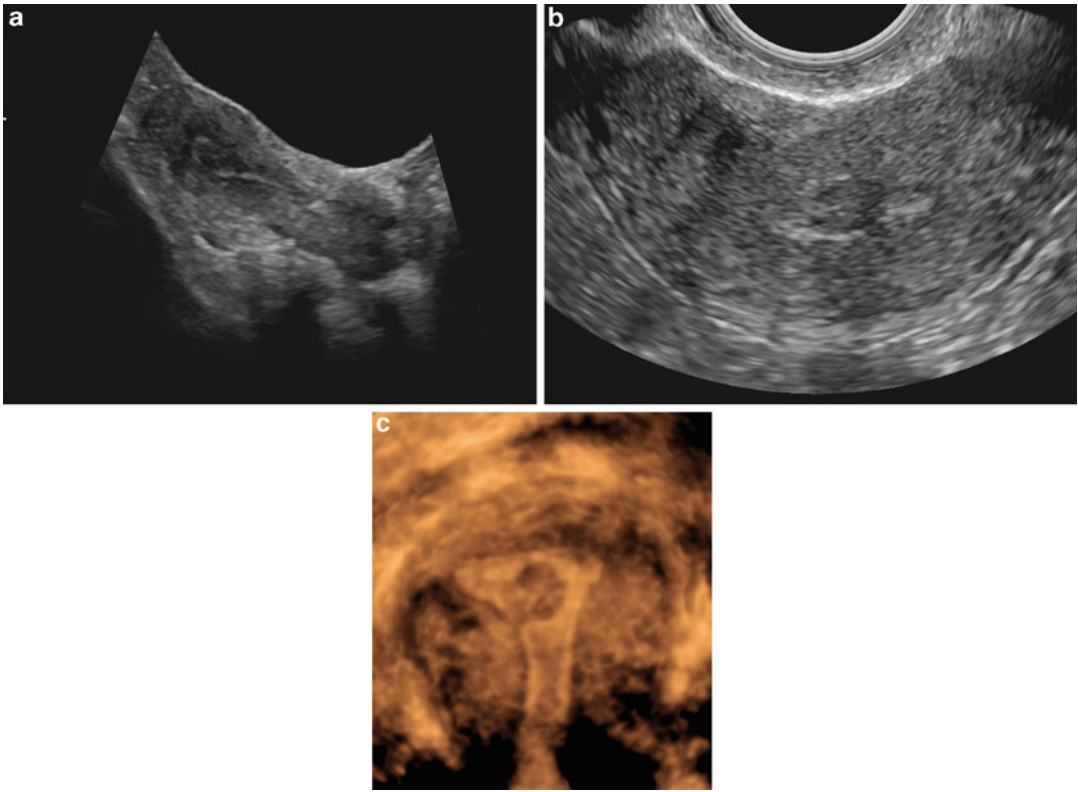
Sonographic images demonstrating an intracavitary fibroid. (a) Sagittal image of the uterus on a transabdominal scan demonstrates a hypoechoic intracavitary mass proven to
